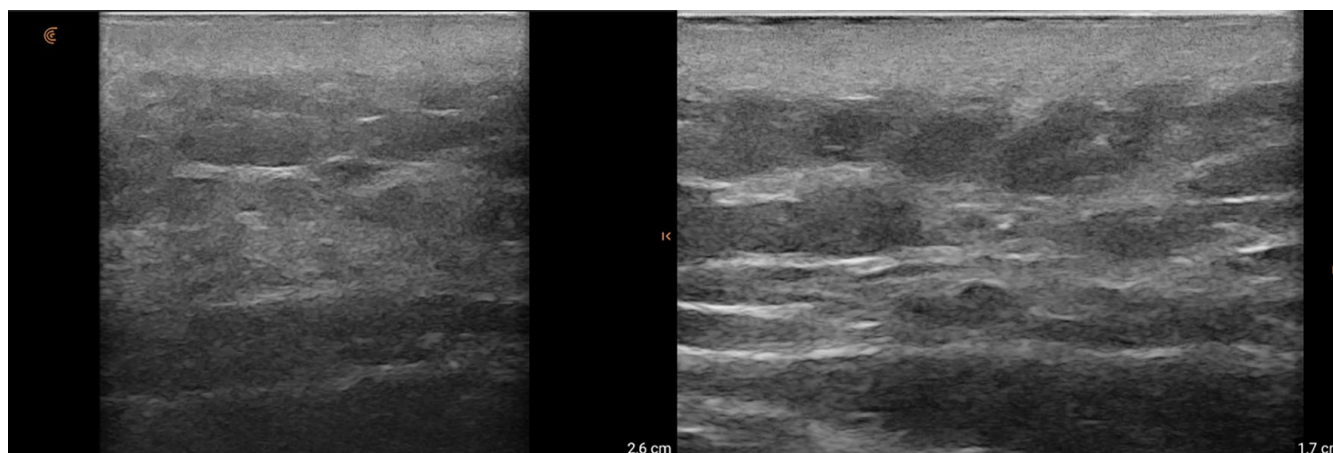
Postoperative ultrasonographic images of the patient at the 1st week and 1st month, obtained using a portable high-frequency ultrasound device (Clarius L20, Clarius Mobile Health, Canada). No irregularities were detected in the imaging.
